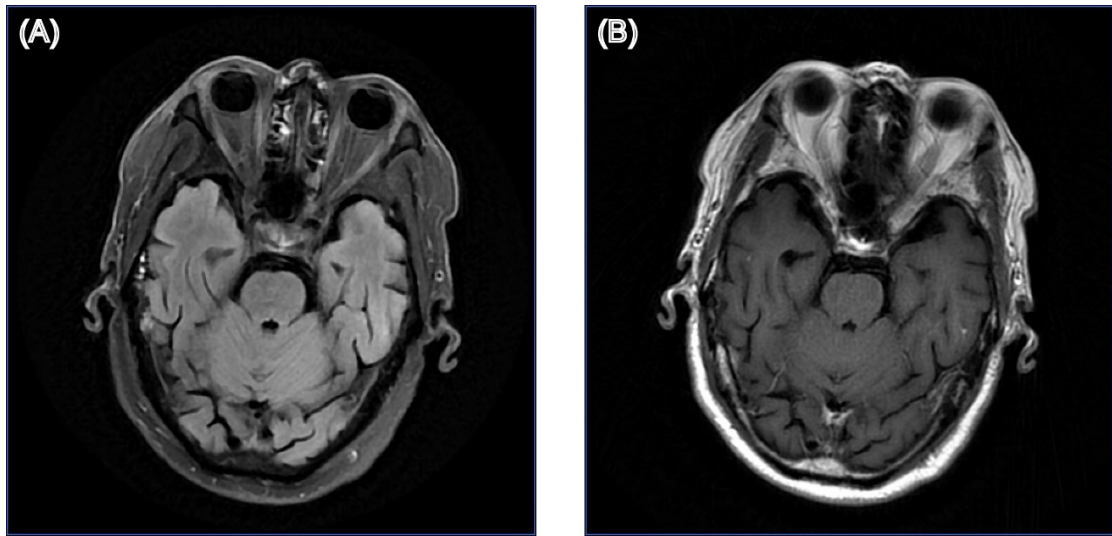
Structural brain MRI images of patient 09. (A) T2-weighted fluid-attenuated inversion recovery (T2-FLAIR) image; (B) Gadolinium-enhanced T1-weighted (Gd-T1w) image.
